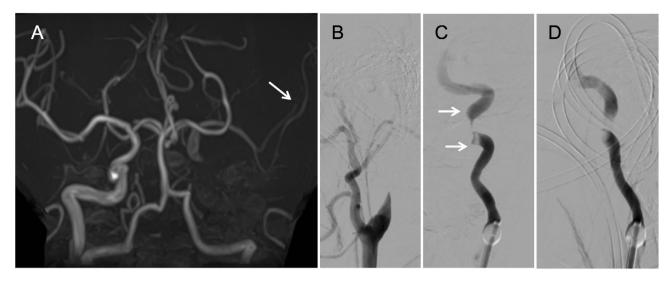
Magnetic resonance imaging and angiography findings in Case 1. (A) Magnetic resonance angiography shows the left ICA and M2 occlusion (*arrow*). (B) Lateral view of the left common carotid angiogram shows the left ICA occlusion. (C) Anteroposterior and (D) lateral views demonstrate occlusive ICA dissection (*arrows*). ICA = internal carotid artery. M2 = insular segment of the middle cerebral artery.
